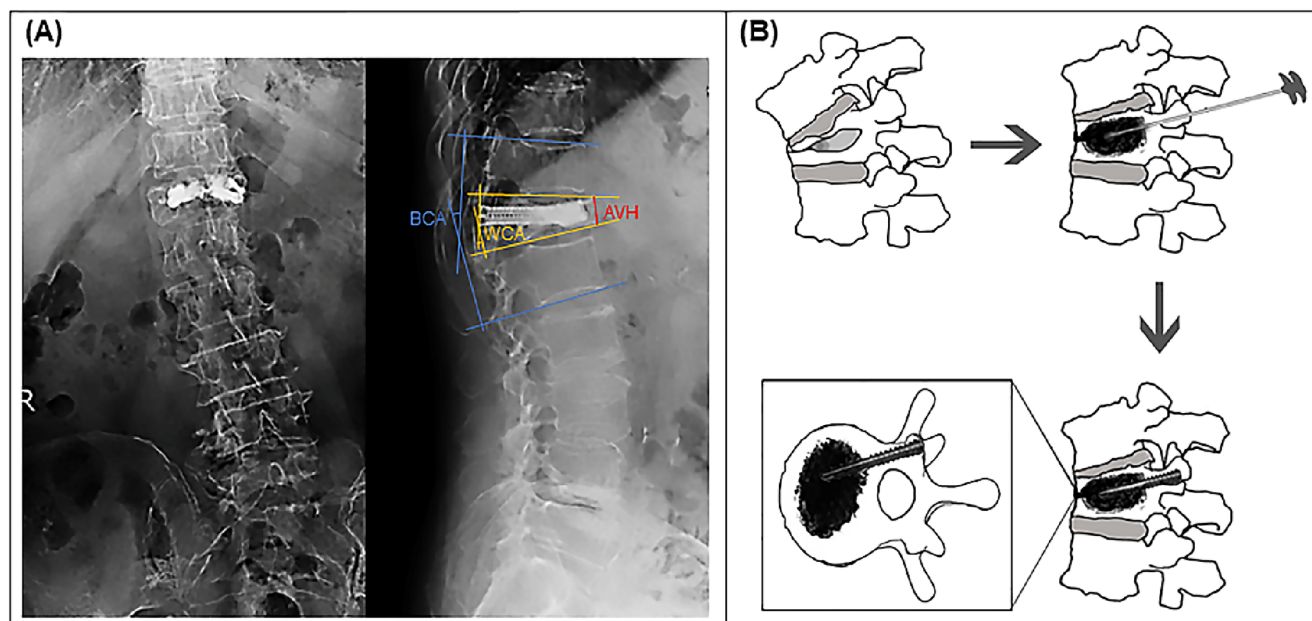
(A) The postoperative anteroposterior (Left) and lateral (Right) radiograph of KD treated with two novel hollow pedicle screws combined with kyphoplasty. AVH: The anterior vertebral height. WCA: The wedge-shaped vertebral Cobb angle. BCA: The biarticular vertebral Cobb angle. (B) A specific surgical procedure.
